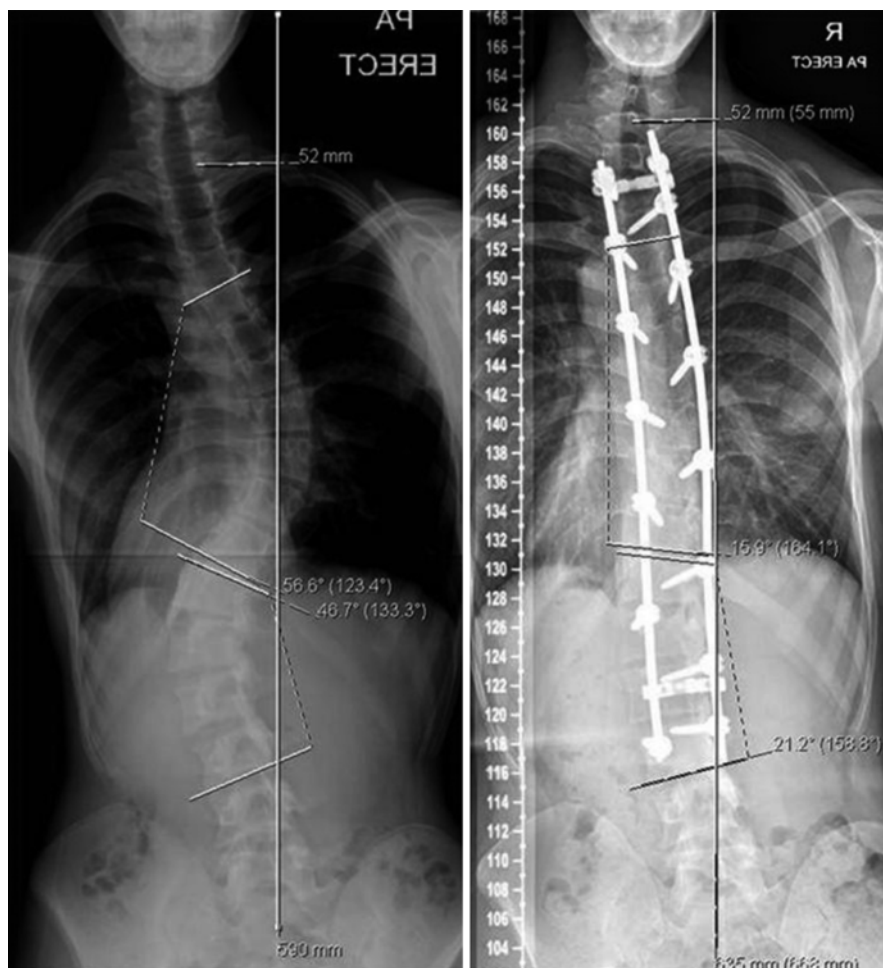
A 15 year old Marfan syndrome boy with adolescent scoliosis treated with posterior instrumented spinal fusion using a low implant density index (IDI) construct. Preoperative and postoperative radiographs are shown
